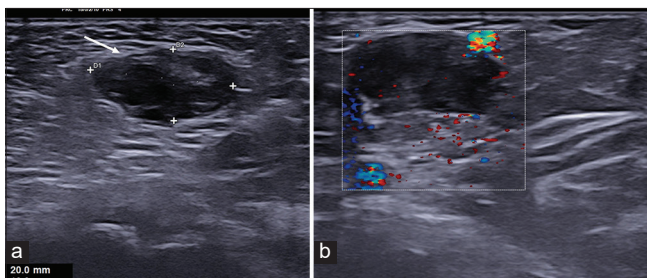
(a and b) Transverse ultrasound using a high-frequency probe at the level of the left inguinal region shows the right ovary (white arrow in a) within the left inguinal region and shows normal vascularity.
